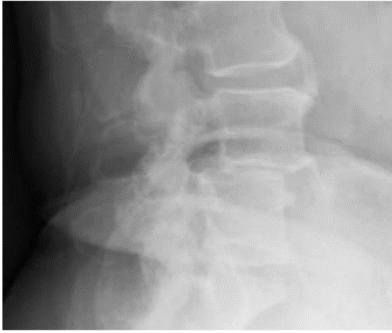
standing lateral radiograph showed L4/L5 degenerative spondylolisthesis [14].
